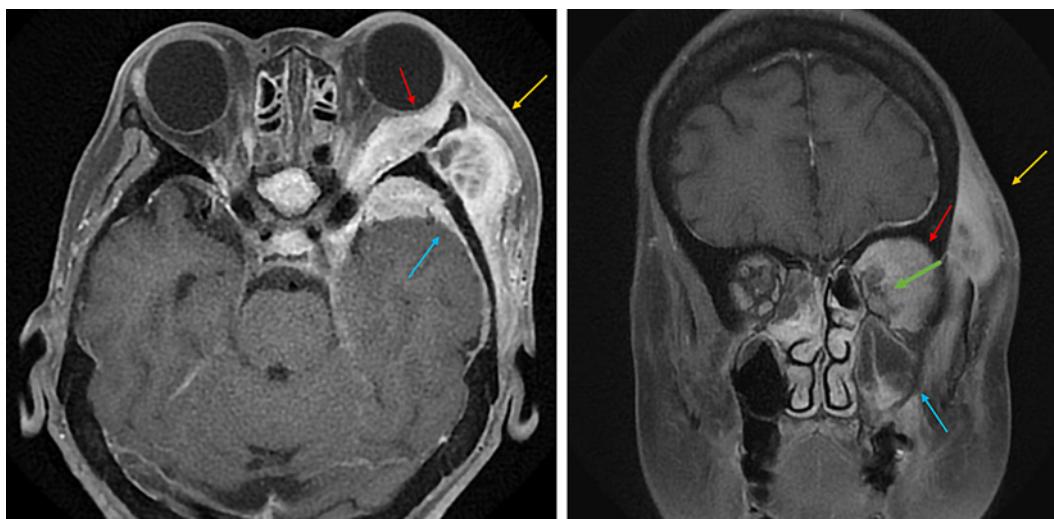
Gadolinium-enhanced MRI of the orbital region revealed hypersignals predominantly in the lateral side of the left orbit (red arrow). The optic nerve and extraocular muscle were compressed by the orbital lesion (green arrow). Abnormal signals spread to the eyelid, subcutaneous temporal region, vicinity of the auricle (yellow arrow), scull base on the ventral temporal lobe, meninges, and maxillary sinus (blue arrow). Inflammation of the maxilla spreads to the inside of the orbit and the meninges via the zygoma and temporal bone on the side wall of the orbit.
